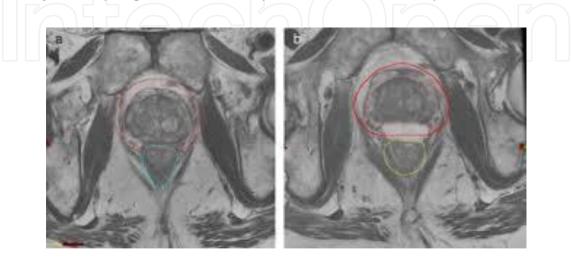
MR images of perirectal sparing with biomaterials and without it.
